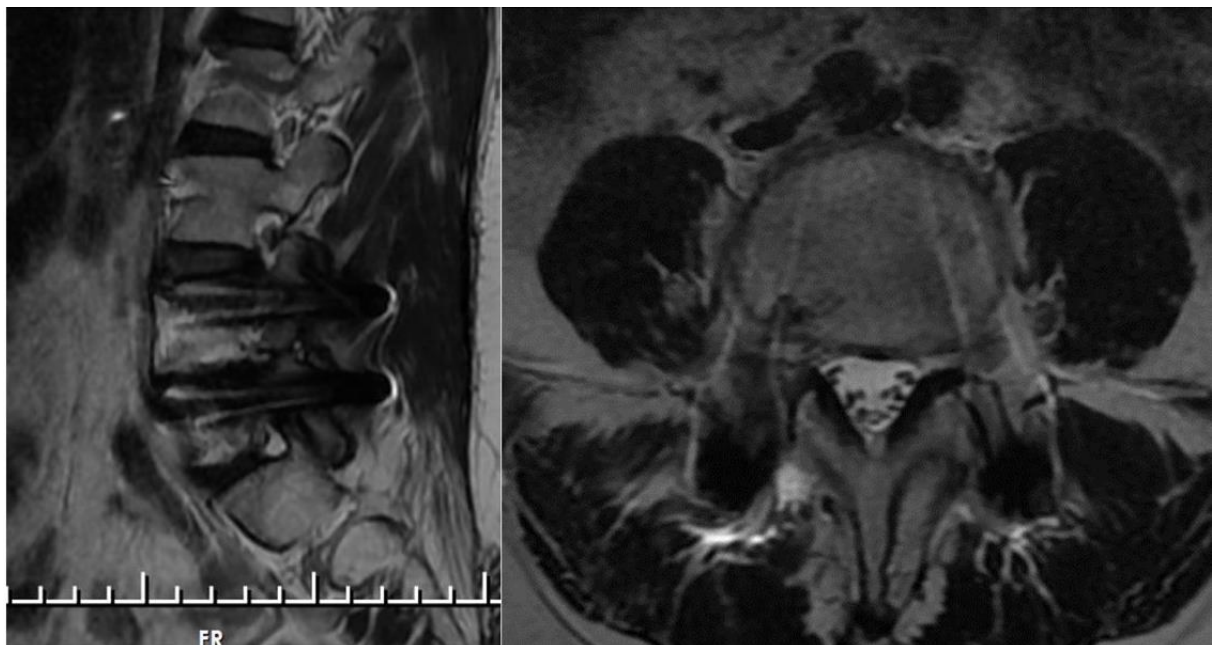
e.f. The patient underwent revision surgery with trans-pars microdiscectomy and fixation surgery with short segment pedicle screw technique. Postoperative sagittal and axial magnetic resonance images.
